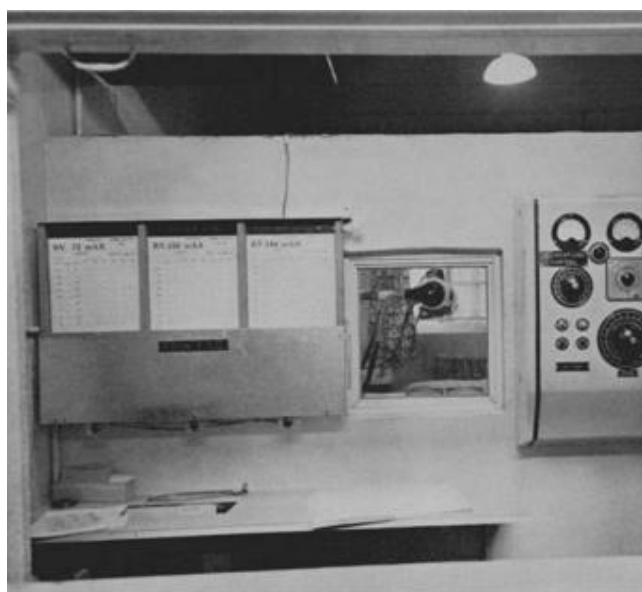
SXT Unit Viewed through a lead glass window, with the x-ray control unit on the right.
